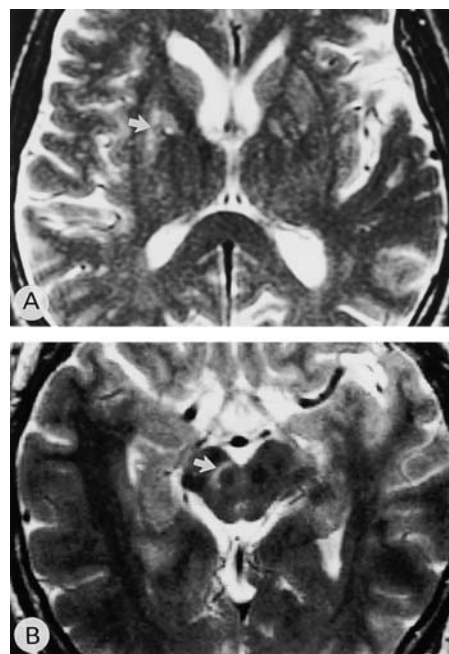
Axial T<sub>2</sub>-weighted MR images obtained 24 hours postoperatively in a patient with PD who received simultaneous intrastriatal and intranigral fetal VM grafts. A: Axial MR image depicting four tracts of graft deposits into the right putamen (arrow). B: Axial MR image depicting a graft deposit into the right SN (arrow).
